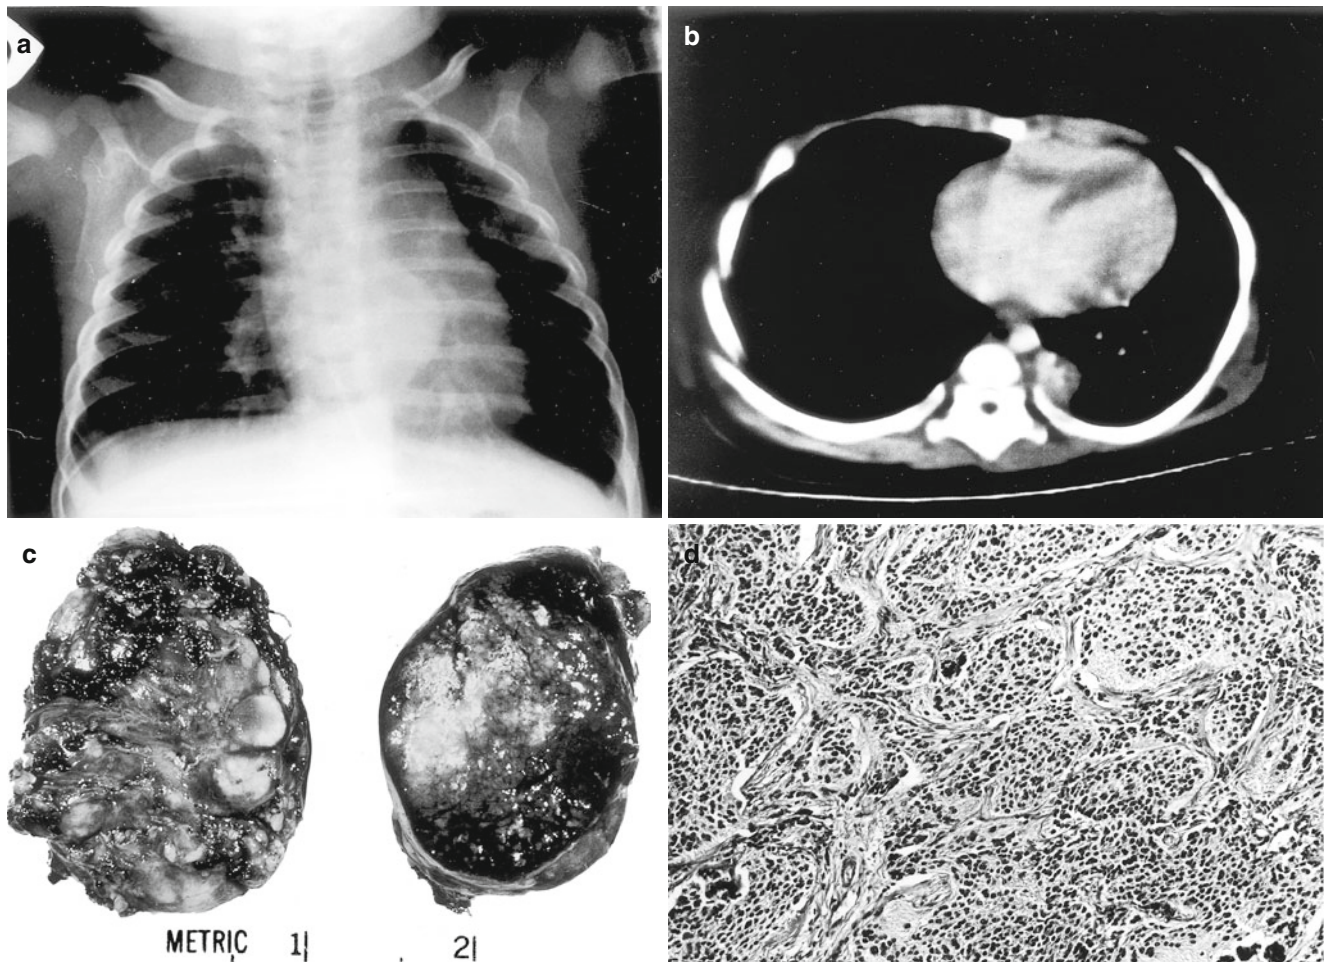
Posterior mediastinal neuroblastoma in a 6-month-old female presenting with a mediastinal mass noted as an incidental finding on a chest film. (a) Chest radiograph reveals a posterior mediastinal mass with calcifications and suggestive hilar lymph node metastases. (b) CT scan shows a 4–5 cm, partially calcified posterior mediastinal mass situated in the thoracic paravertebral region. (c) The tumor, 5.1 g, 2.2×1.7 cm, has a dark-red, nodular capsular surface (*left side*) and a
